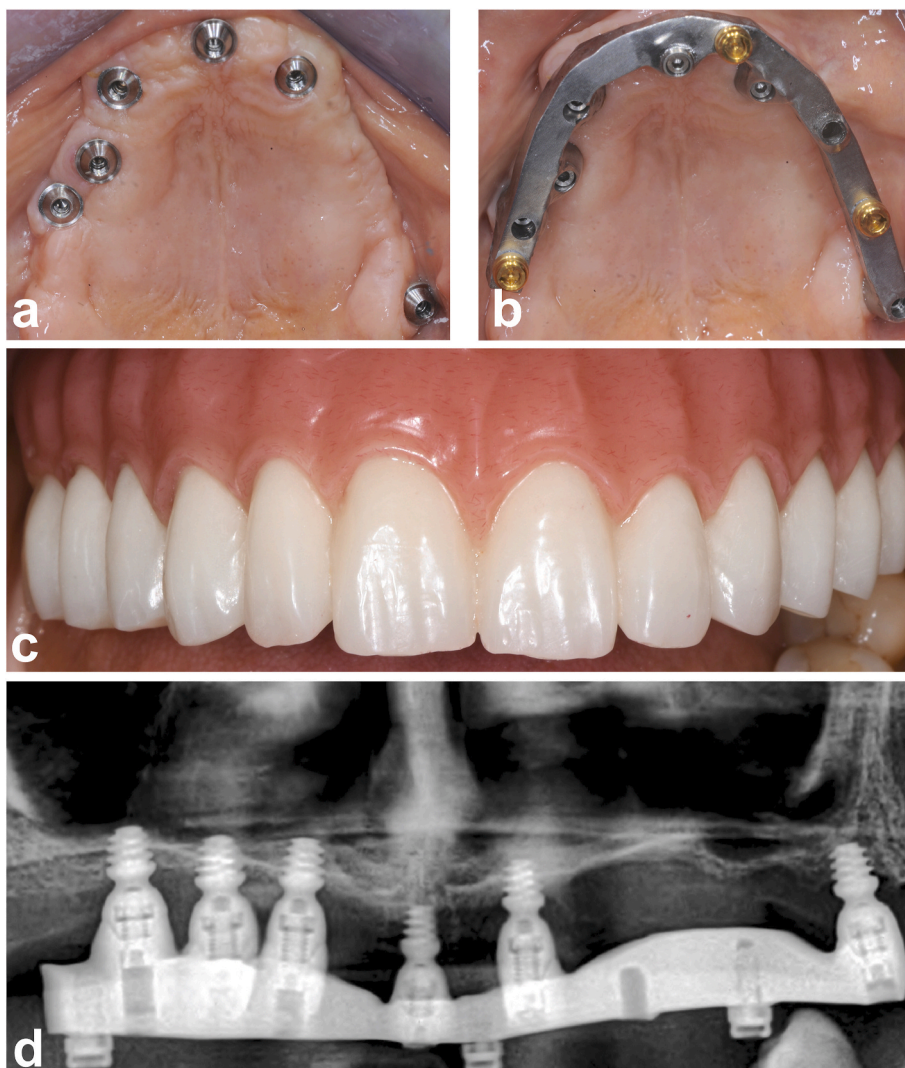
(a–d): Delivery of the bar-retained overdenture (OVD) prosthesis: (a) tissues appearance, (b) milled bar in place, (c) clinical and (d) radiographic (OPG) OVD prosthetic views.
